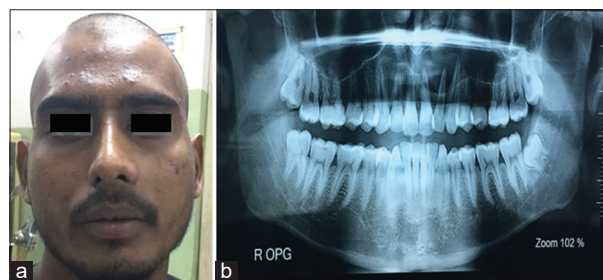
(a) Clinical picture showing obliterated nasolabial fold on the left side, (b) Orthopantomogram depicting radicular cyst margin engulfing maxillary sinus (Case 6)
